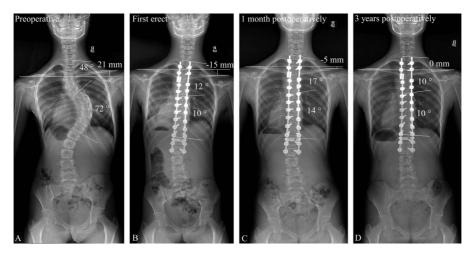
A-D A 12-year-old girl underwent deformity correction and posterior fusion (T2 to L2) using convex compression with separate-rod derotation. (A) This preoperative image shows a proximal thoracic curve of 48° with right-shoulder-up of 21 mm. (B) At the first erect radiograph, the proximal thoracic curve was corrected to 12° with a correction percentage of 75%. There was a right-shoulder depression of 15 mm. (C) Shoulder balance was improved at 1 month postoperatively and (D) was level after 3 years of follow-up.
